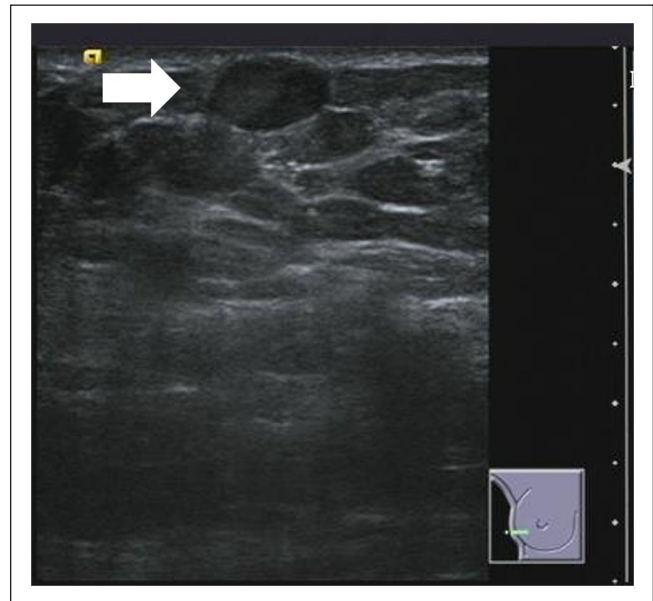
Ultrasonography shows a solid mass lesion subcutaneously in the lateral region of the right breast.
